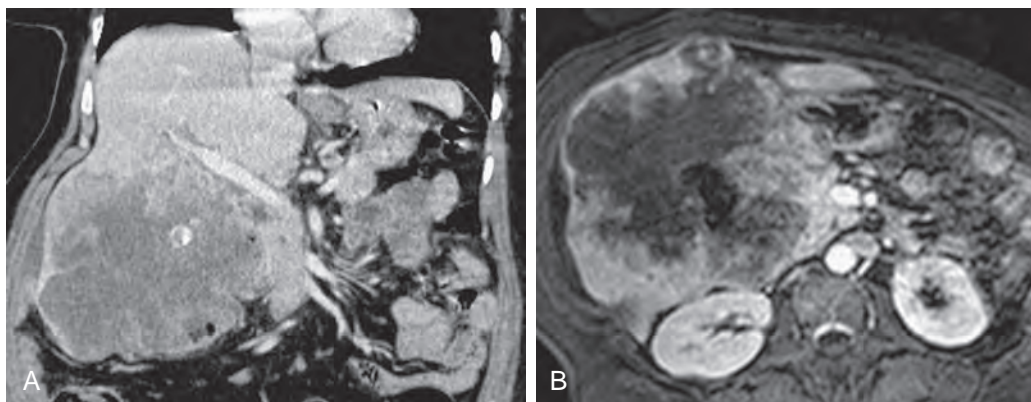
Gallbladder adenocarcinoma. Coronal CT (A) and axial post-gadolinium fat-saturated (B) images demonstrate a large heterogeneous mass originating in the gallbladder fossa. Calcified gallstones within the center of the mass are seen on the CT image.
